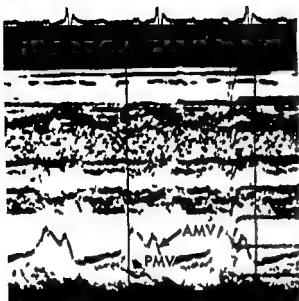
The ultrasound record of the patient referred to in Fig 7 taken after correction of Bjork valve dysfunction. The anterior (AMV) and posterior (PMV) leaflets of the mitral valve are seen. There is no fluttering of the anterior mitral leaflet.
